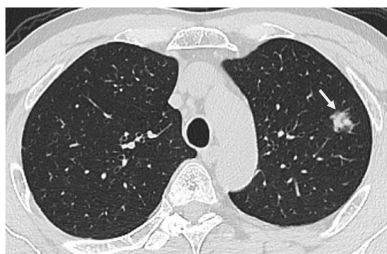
Non-enhanced two-dimensional CT images of a lesion.
